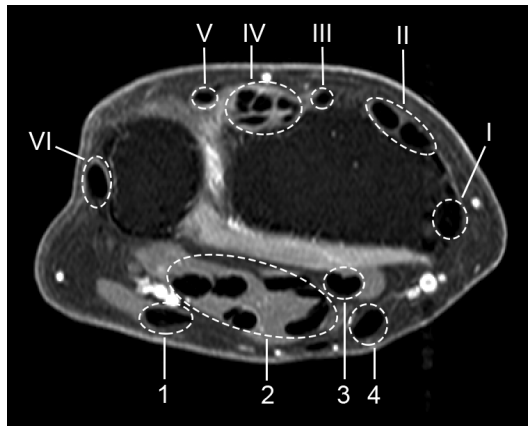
Tendon regions (compartments) scored for tenosynovitis, shown on axial MR image of the wrist (T1, post-gadolinium, fat-saturated). The six defined extensor compartments contain: abductor pollicis longus, extensor pollicis brevis (I); extensor carpi radialis longus, extensor carpi radialis brevis (II); extensor pollicis longus (III); extensor digitorum communis, extensor indicis proprius (IV); extensor digiti quinti proprius (V); extensor carpi ulnaris (VI). The four flexor regions contain: flexor carpi ulnaris (1); ulnar bursa, including flexor digitorum profundus and superficialis tendon quartets (2); flexor pollicis longus (tendon) in radial bursa (3); flexor carpi radialis (4). Note: the flexor carpi ulnaris does not have a tenosynovial sheath; nevertheless, inflammation around this tendon is also observed, and therefore enhancement of tissue surrounding this tendon is scored [11].
